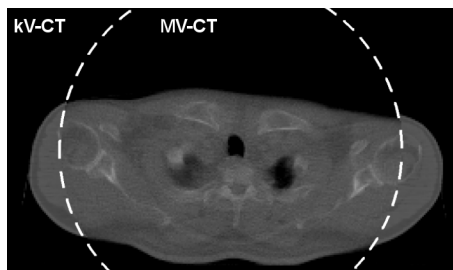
One slice of a merged CT consisting of a MV-image in the center and of small, initial kV-CT parts to fill the area outside of the (smaller) MV-CT’s field of view.
